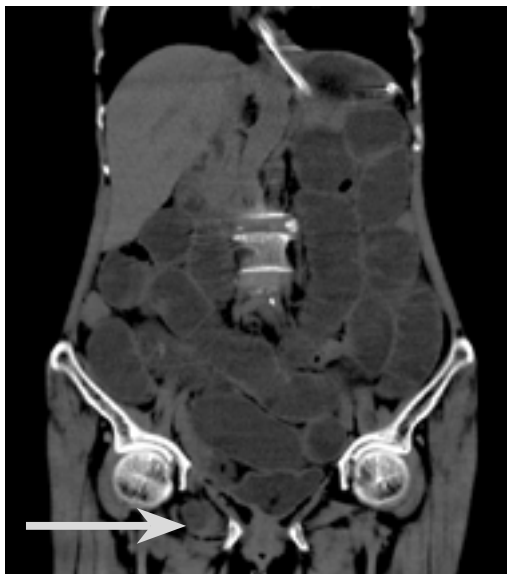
CT Abdomen Showing Obstructed Obturator Hernia
